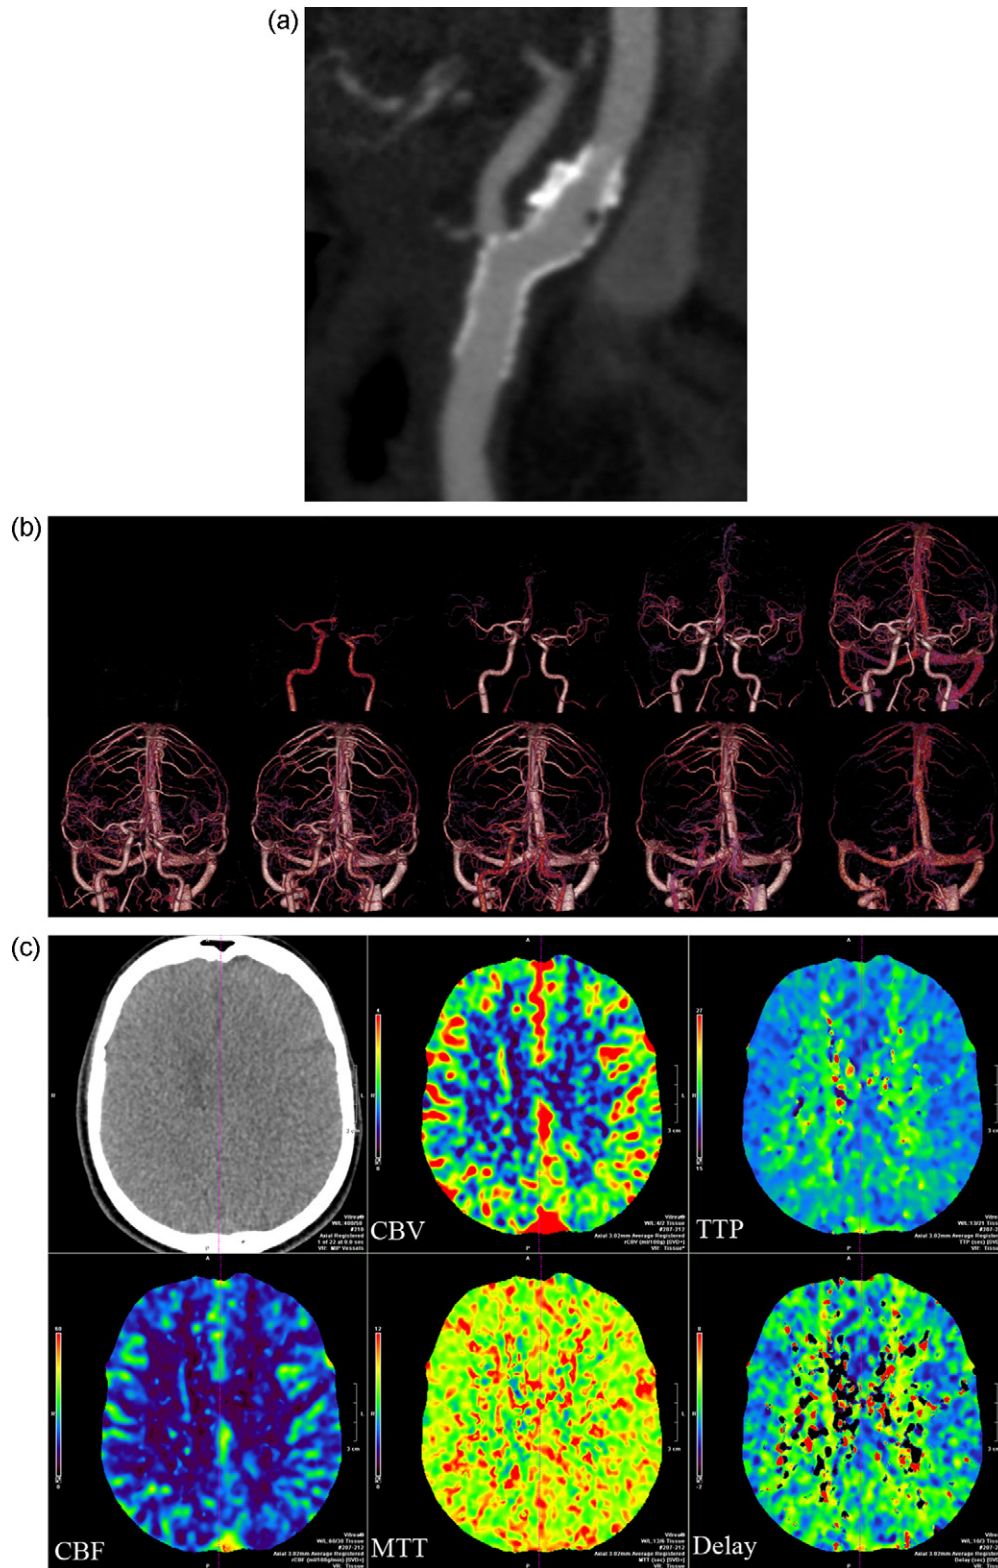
Supra-aortic trunks CTA, WHSDCTA and WBCTP after stenting: (a) sagittal reconstructions showing the stent across the distal CCA and proximal ICA with no residual stenosis; (b) WHSDCTA showing simultaneous filling of the left and right anterior circulations after stent placements; (c and d) axial and coronal perfusion maps showing normalization of the TTP; (e) left lateral projections of surface rendered 3D reconstructions of the perfusion maps showing normalization of the TTP.
